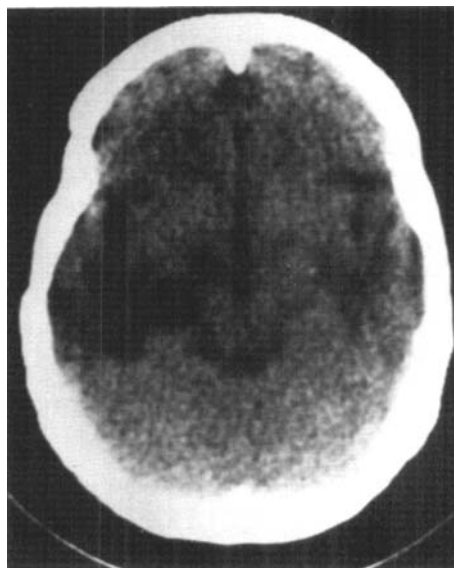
CT in 1990 showing an irregular hypodense lesion in the left temporal lobe in addition to residual hypodensity in the right temporal lobe.
